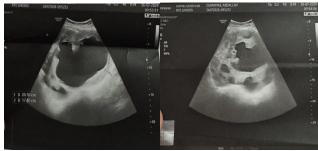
Pelvic ultrasound showing a voluminous 20 cm abdominopelvic tissue mass extending into the epigastric region.
